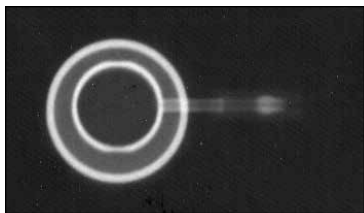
Top or bottom view x-ray image of the Access Port
